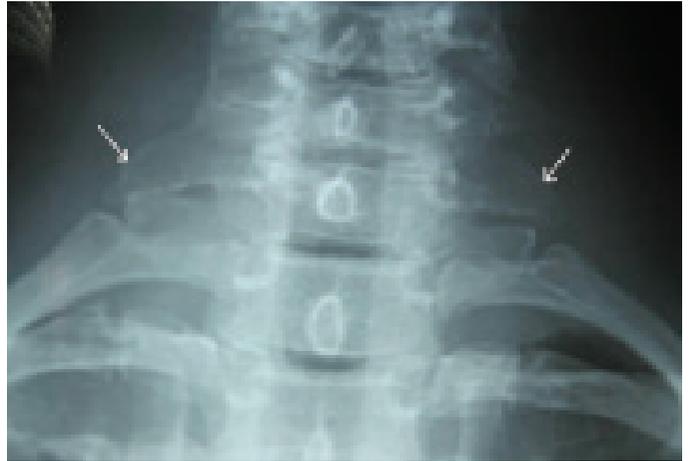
Bilateral prominent C7 transverse processes on radiography of the cervical vertebral column of the Case 1.
